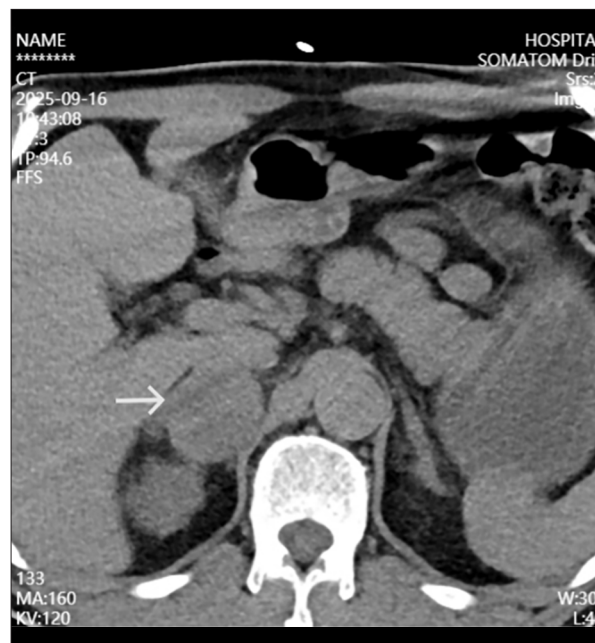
Abdominal computed tomography. Axial contrast-enhanced computed tomography scan revealing a well-defined right adrenal mass (arrow) exhibiting heterogeneous enhancement and imaging features characteristic of pheochromocytoma.
